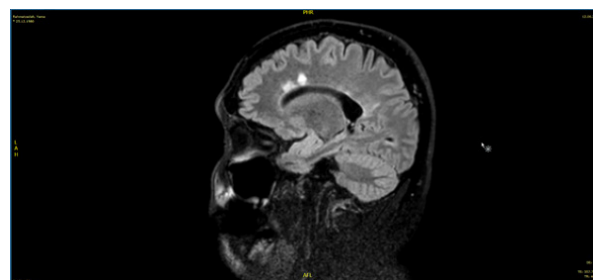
Periventricular demyelinating lesions (MRI-June 12, 2019).
